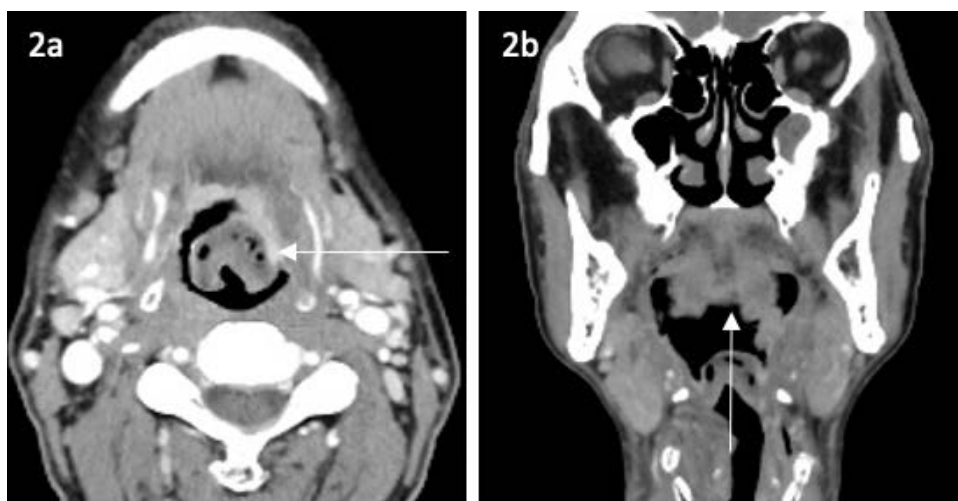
A 57-year-old man presented to the ED with persistent fever and odynophagia that did not improve with antibiotics. (a) Axial and (b) coronal contrast-enhanced CT images showed multiple gas loculi within the epiglottis, suggestive of a gas-forming infection with surrounding inflammatory soft tissue changes.
